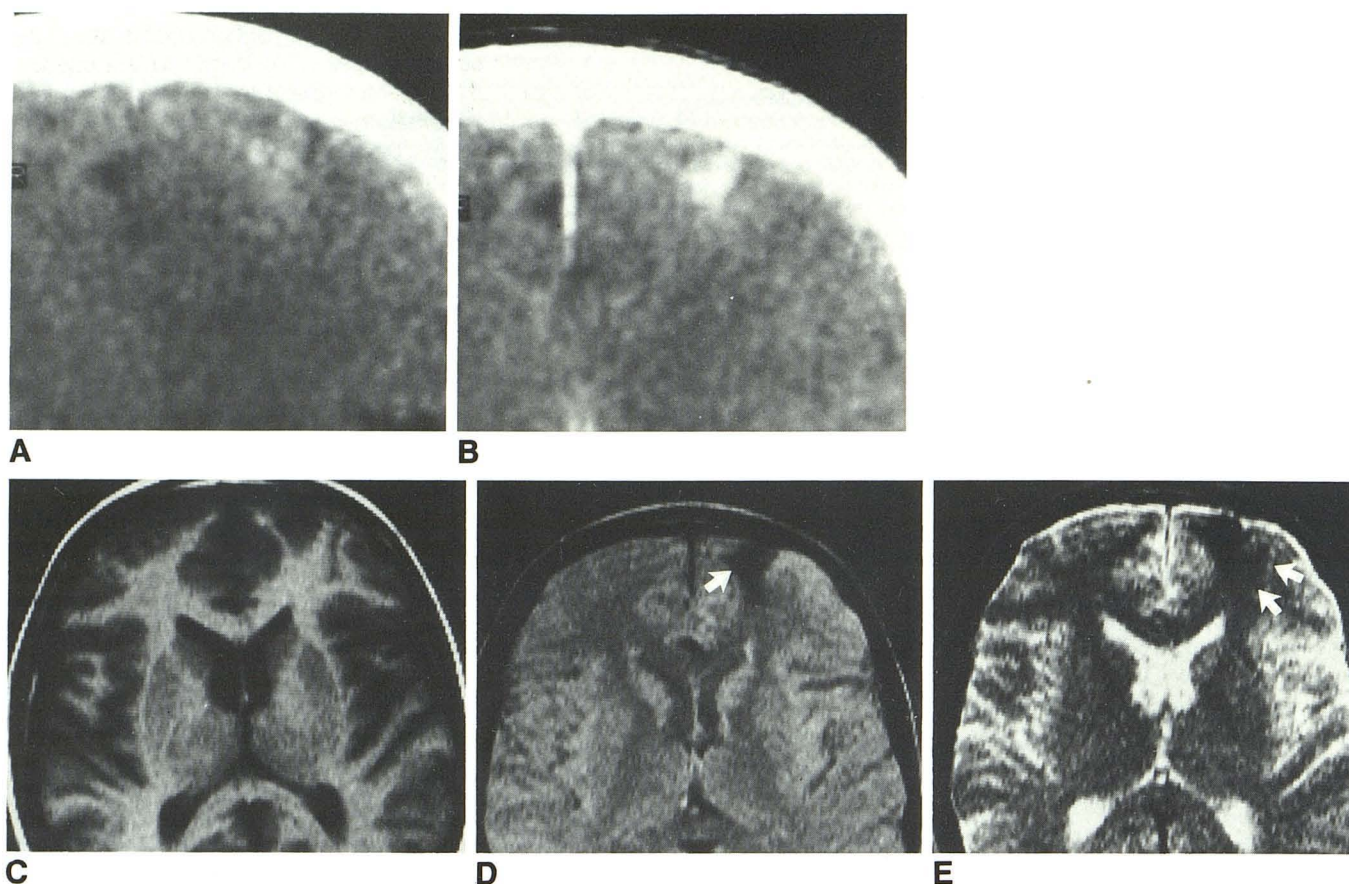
Case 6. A, Plain CT shows small hyperdense region in anterior left frontal lobe region, involving the cortex. Small granular calcifications are apparent. B, After intravenous contrast, area shows mild contrast enhancement surrounding calcifications. MR was performed 3 months after CT. C, IR 1500/450/4 sequence. A region of low signal, indicating T1 somewhat longer than gray matter, is shown extending from cortex into subcortical white matter. No mass effect is evident. D, SE 2000/60/2. The region of lesion (arrow) shows
